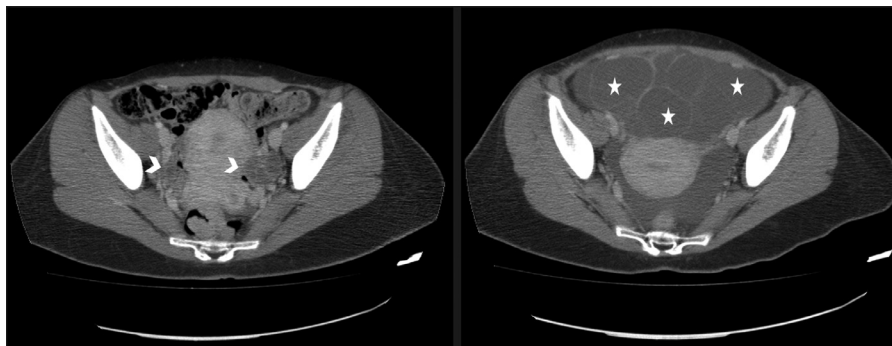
Development of b-hCG induced ovarian hyperstimulation syndrome. Axial contrast-enhanced CT images, venous-phase, on the left first imaging evaluation with normal ovaries (arrowheads). On the right subsequent check shows enlarged ovaries with multicystic masses (stars) due to progressive hormonal stimulation. a rare case of spontaneous OHSS associated with extragonadal b-hCG -secreting tumor.
